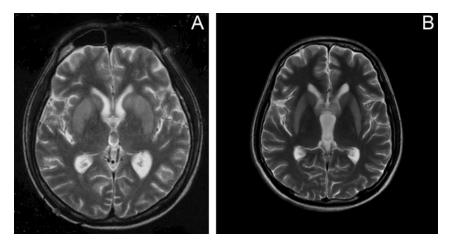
MRI T2WI of case 1 (A) and case 2 (B) showed symmetrical hypersignal intensity lesions at caudate and putamen with pallidal sparing
